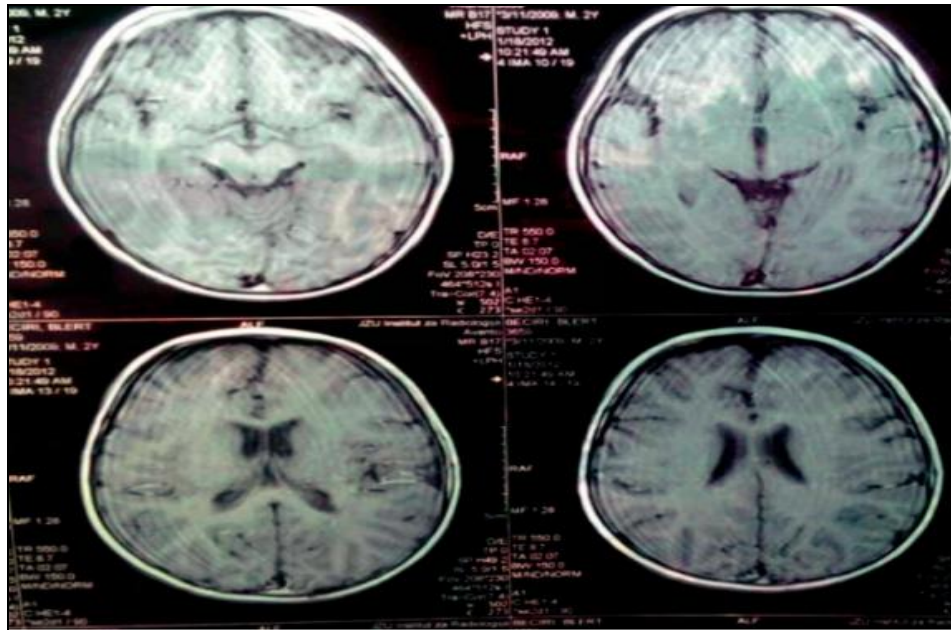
MRI of the brain with slight dysmorphism of the frontal gyri
